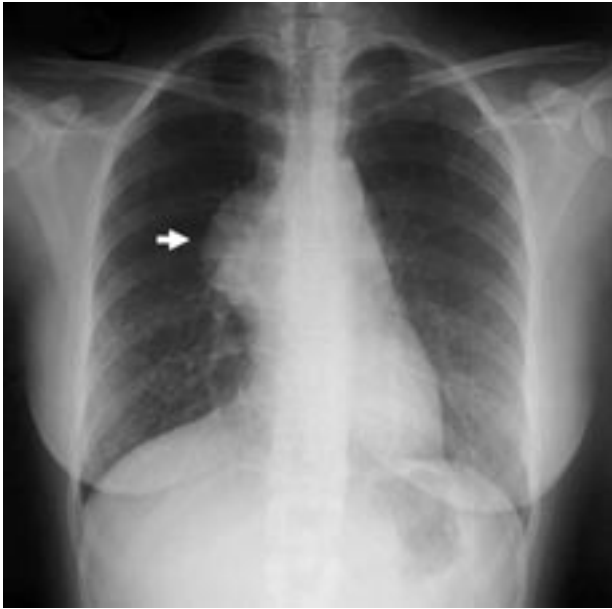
Chest X-ray showing a large mediastinal mass.
